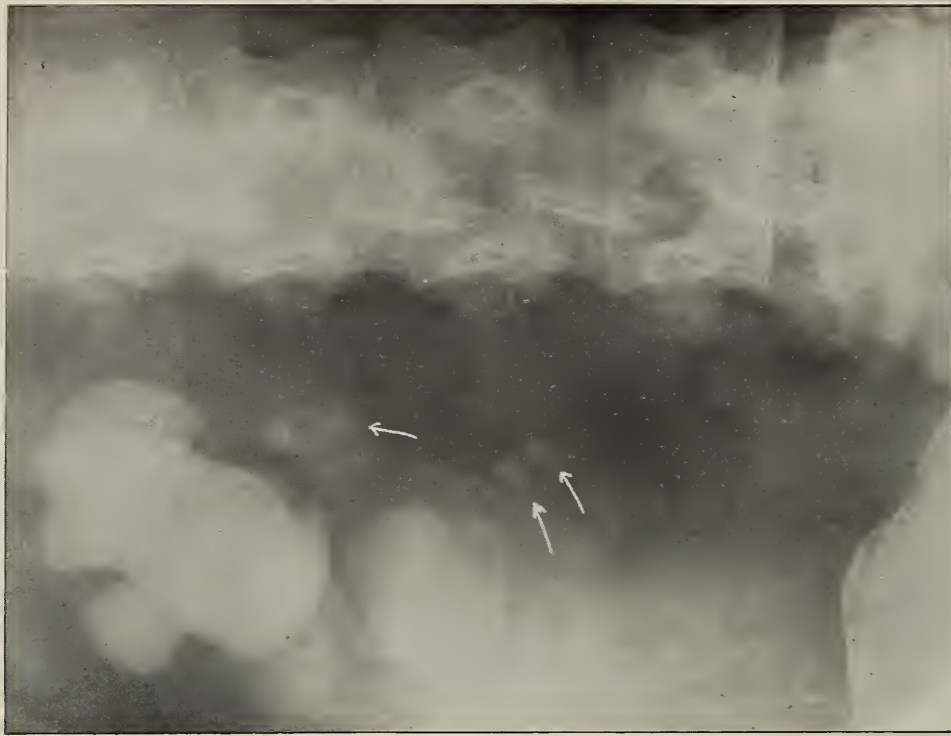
X-ray No. 13159, b. Colloidal silver injection shows considerable hydronephrosis. Note change in position of large calculus, having been pushed up an inch by introduction of catheter. At operation larger calculus obstructed ureter at ureteral-pelvic junction. Two small stones removed from cortex of lower pole.
